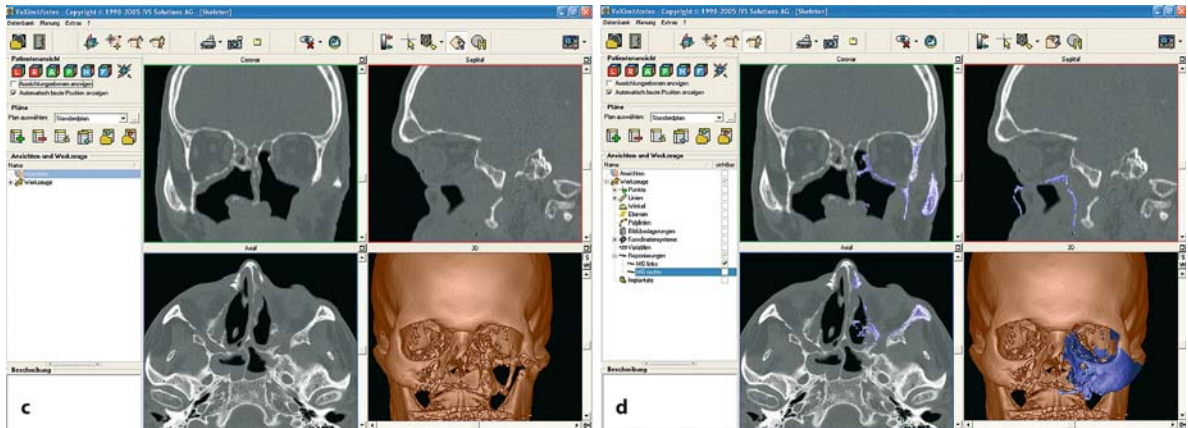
(continued) The CT images show the extent of the defect (c). A virtual surgical template is created by segmentation and mirroring of the opposite side. This template predefines the contours of the ideal reconstruction (d)
